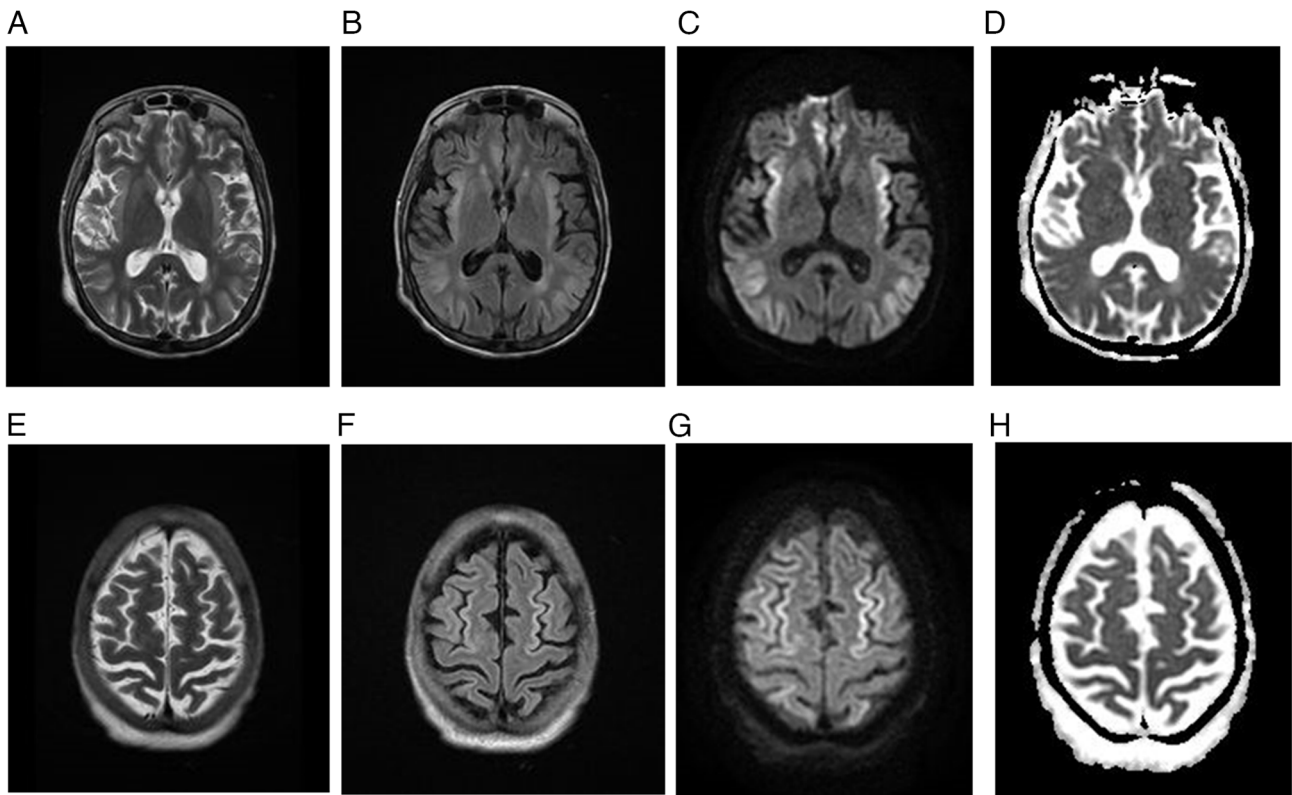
Follow-up MRI brain scan for case 5. (A) T2-weighted MRI, (B) FLAIR and (C) diffusion-weighted imaging demonstrating complete resolution of the cortical T2 and FLAIR high signal intensities, with marked bilateral symmetrical brain atrophy. MRI, magnetic resonance imaging; FLAIR, fluid attenuated inversion recovery.
